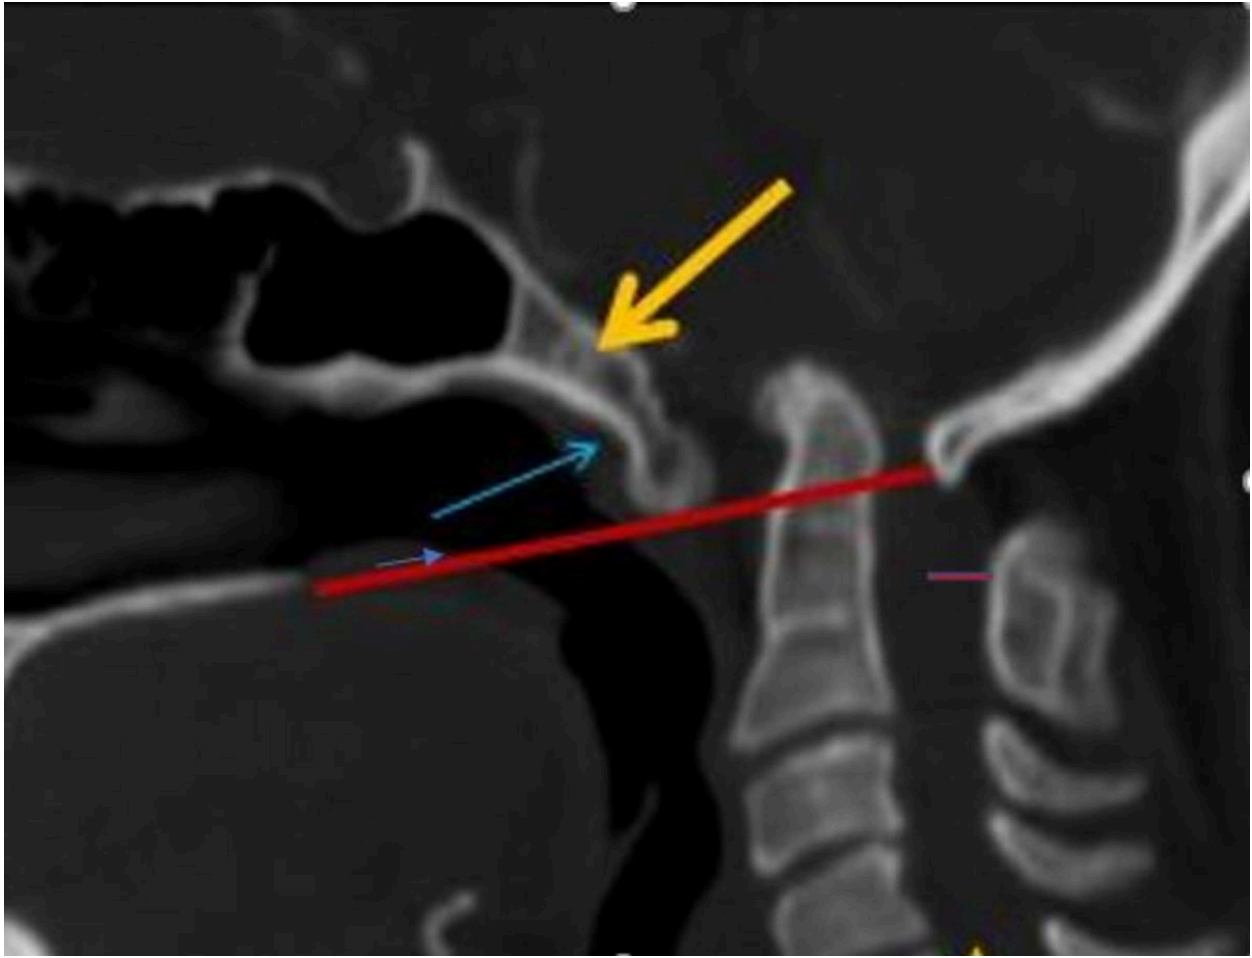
CT sagittal section depicting short clivus(yellow), atlantooccipital assimilation(blue) and disturbed chamberlain's line(red) suggestive of basiocciput hypoplasia.
